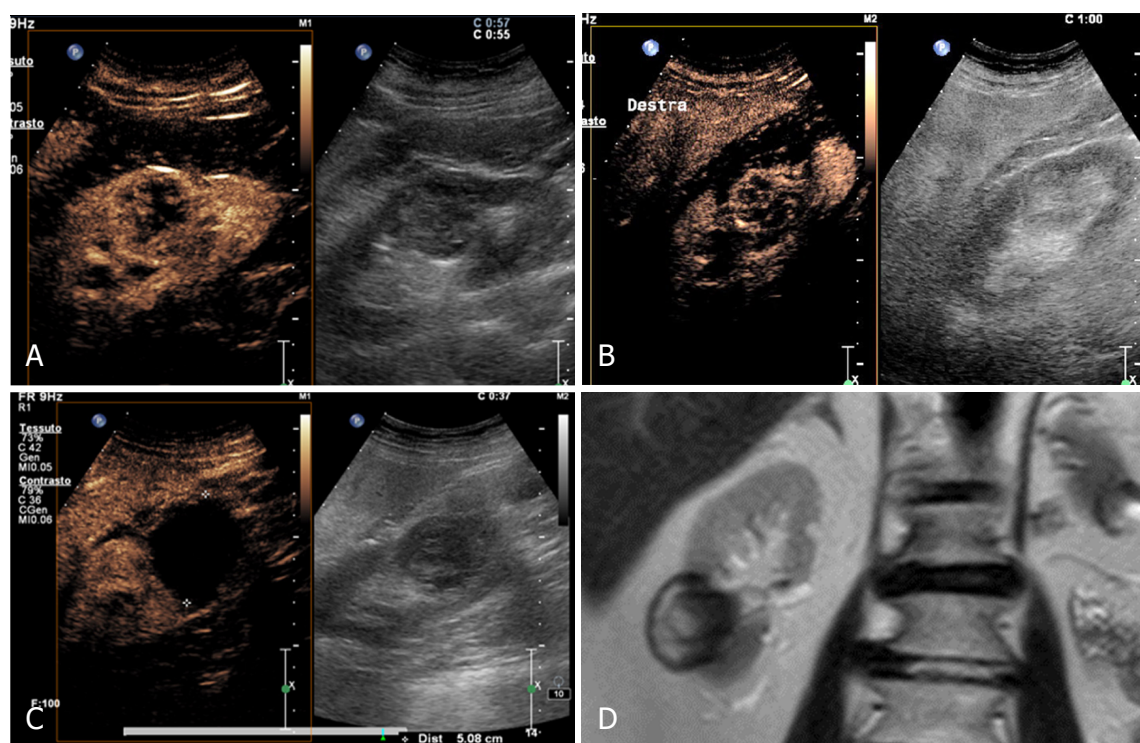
Follow-up after cryoablation. A: 84 years old patient with 5 cm RCC; B: Postoperative day 1 and enhancement; C: no tumor persistence and often a repeated CEUS after 1 month is recommended in lesions that maintain vascularity on postoperative to exclude residual tumor; D: MR after 6 months confirms the success of the cryoablation treatment. CEUS: contrast enhancement ultrasonography; RCC: renal cell carcinoma
